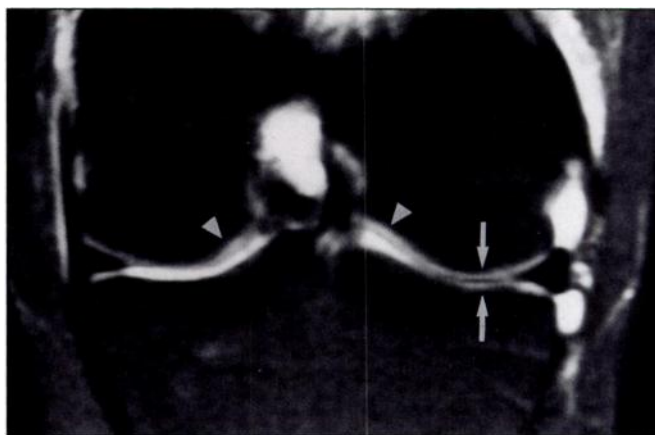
Normal hyaline cartilage in 23-year-old woman. Coronal T2-weighted fast spin-echo image with fat saturation (TR/TE, 3000/38) reveals normal thickness and signal intensity of hyaline articular cartilage of weight-bearing surfaces of lateral compartment (arrows). Increased signal intensity within curved portions of otherwise normal-thickness cartilage (arrowheads) is believed to represent magic angle phenomenon.
